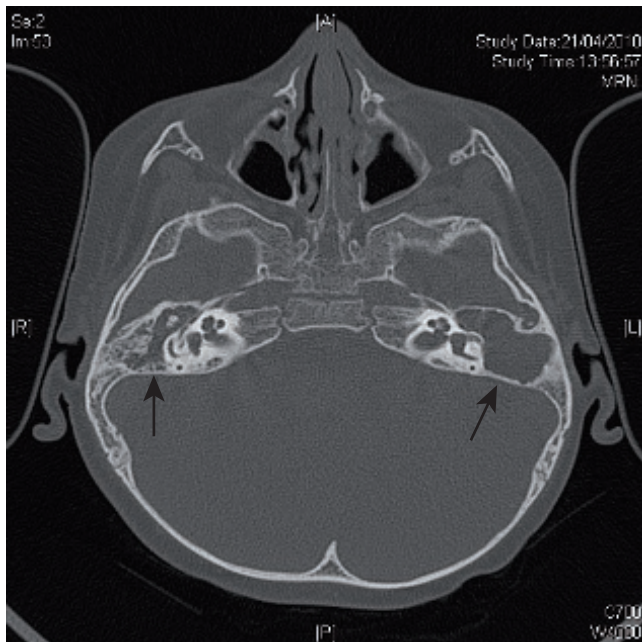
Axial CT scan in a 5-year-old child. Arrows show mastoid opacification on both sides due to bilateral cholesteatoma, with erosion of the lateral semicircular canal on the left.
